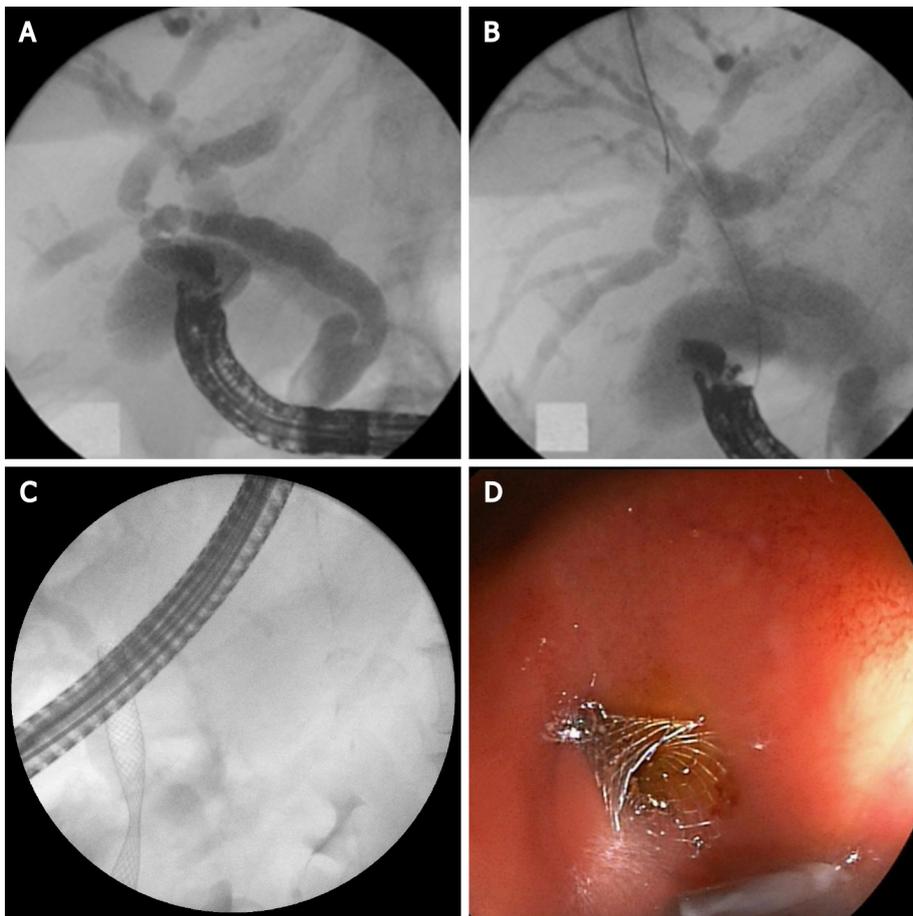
Endoscopic ultrasound-guided choledochoduodenostomy. A: Puncture of the common bile duct with 19G needle and contrast injection; B: Hydrophilic guidewire inserted through the needle into bile ducts; C: Fluoroscopic image of self-expandable metal stent (SEMS); D: Endoscopic image of SEMS.
